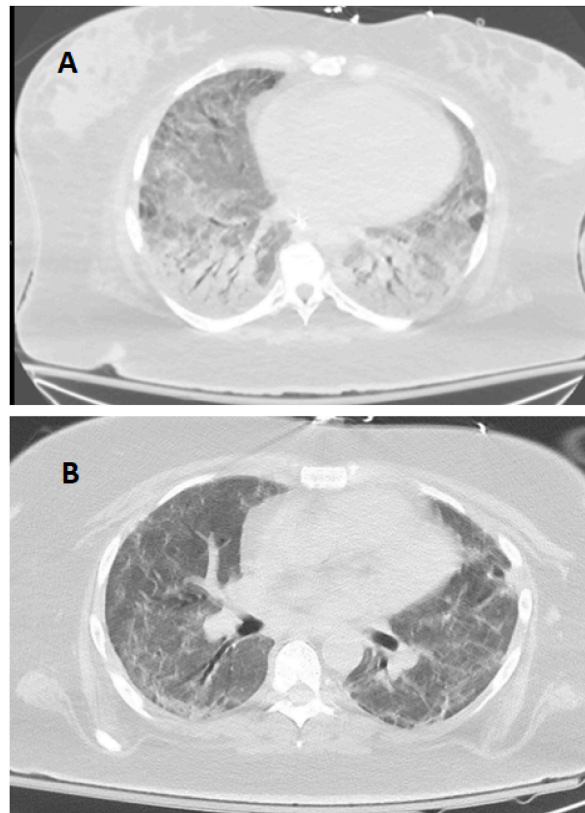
A. Chest CT imaging before five-day course of IP (February 8, 2022). B. Chest CT showing improvement after five-day course of IP (March 8, 2022).
